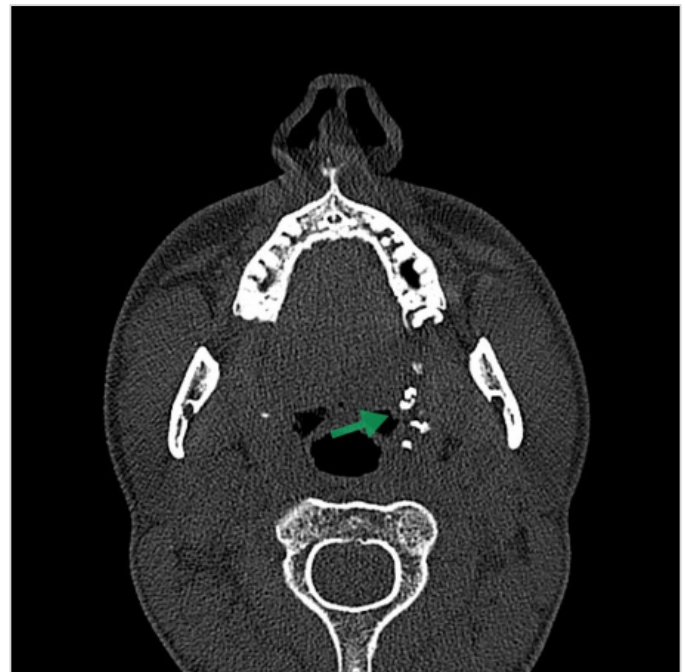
Axial CT image of multiple TLs in the left palatine tonsil (axial)
